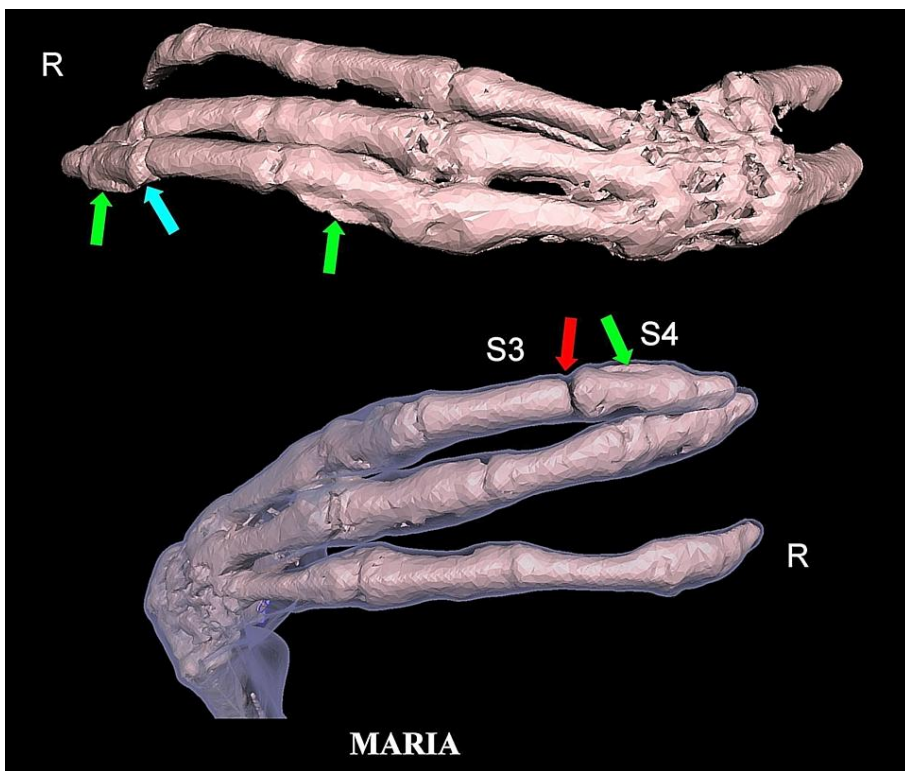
3D CT showing bones in right hand (*upper*) with skin in semi-transparency (*lower*). Note the amputation in the most distal part of S3 segment of medial digit (*red arrow*) and the partial subluxation of segments S3/4 interphalangeal joint (*blue arrow*). Asymmetric subperiosteal bony thickenings (*green arrow*) were present in S2 and S4 segments of the medial digit.
